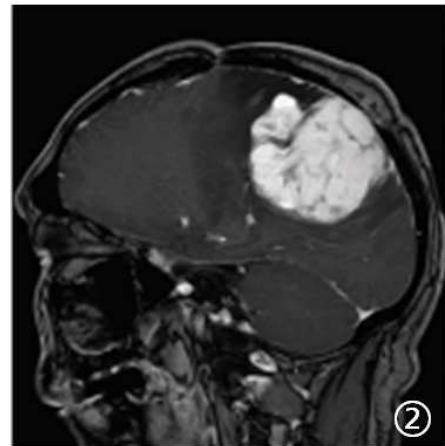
CT and MRI images of the 2 cases: the mass is located in Right top, size 6.7cm \times 5.0cm \times 6.0cm.
